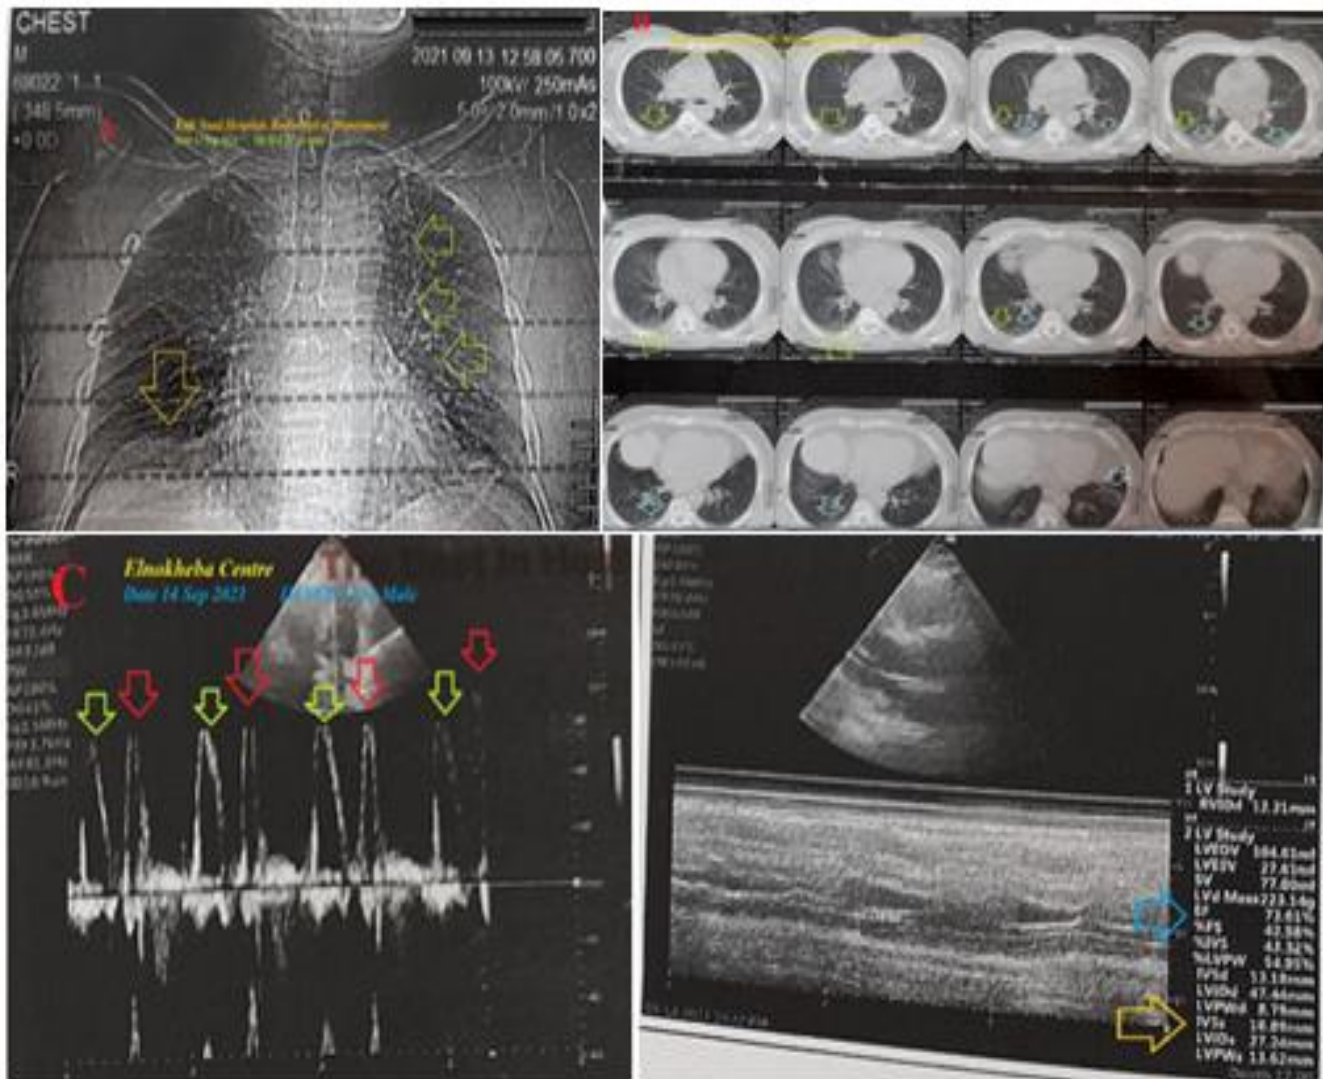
(A). CXR plain film was done during the second day of the presentation showing mild right pleural effusion (golden arrow) and mild left parahilar ground-glass opacities (lime arrows). (B). Chest CT without contrast was done during the second day of the presentation showing mild right pleural effusion (lime arrow) and mild left parahilar ground-glass opacities (light blue arrows). (C). Echocardiography was done during the third day of the presentation with EF; 73.61 % (light blue arrow) showing diastolic dysfunction with reversed EA ratio (lime and red arrows) and IVS hypertrophy (18.89 mm; orange arrow).
